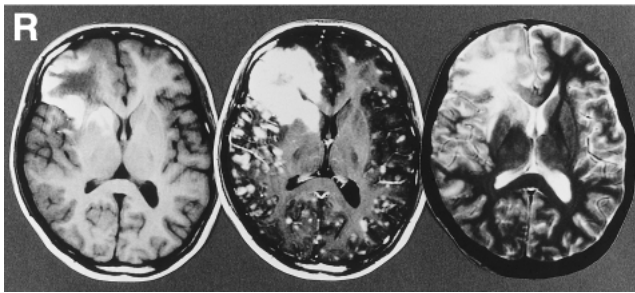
T₁- (left) and T₂-weighted (right) magnetic resonance (MR) images showing mixed intense lesions without clear margins in the right frontal lobe. T₁-weighted MR image after gadolinium administration (center) showing intense enhancement of the right frontal lesion and multiple nodules in the meningeal/intraparenchymal regions.
